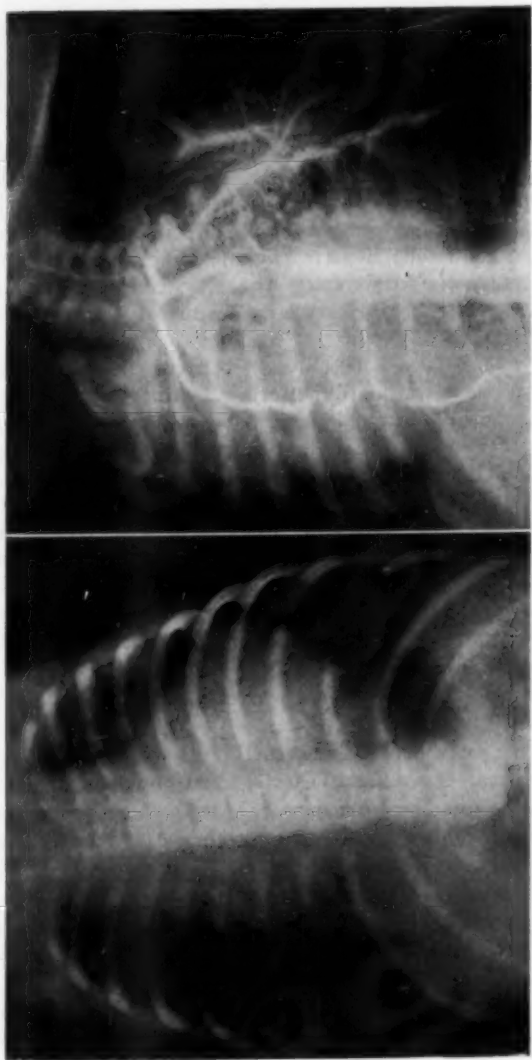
Roentgenogram on the left shows marked cardiac enlargement in an infant of 10 weeks. Aortogram on right demonstrates a coarctation of the aorta.
